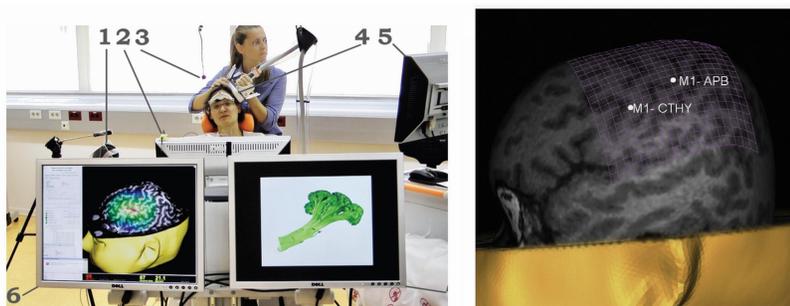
nTMS mapping in healthy subjects. Left: Subject during a visual object-naming task with the examiner holding the coil on the dominant hemisphere. 1 = microphone connected to electromyography amplifier, 2 = monitor with the visual object presented to the subject with the attached photo sensor for picture onset registration, 3 = microphone connected to the video camera, 4 = magnetic coil for nTMS, 5 = monitor with MRI for precise determination of stimulation site, 6 = cloned monitor 5 for video shooting, and 7 = cloned monitor 2 for video shooting. Right: cortical locations of M1 for hand and laryngeal muscle shown for the left hemisphere. CTHY=cricothyroid muscle
